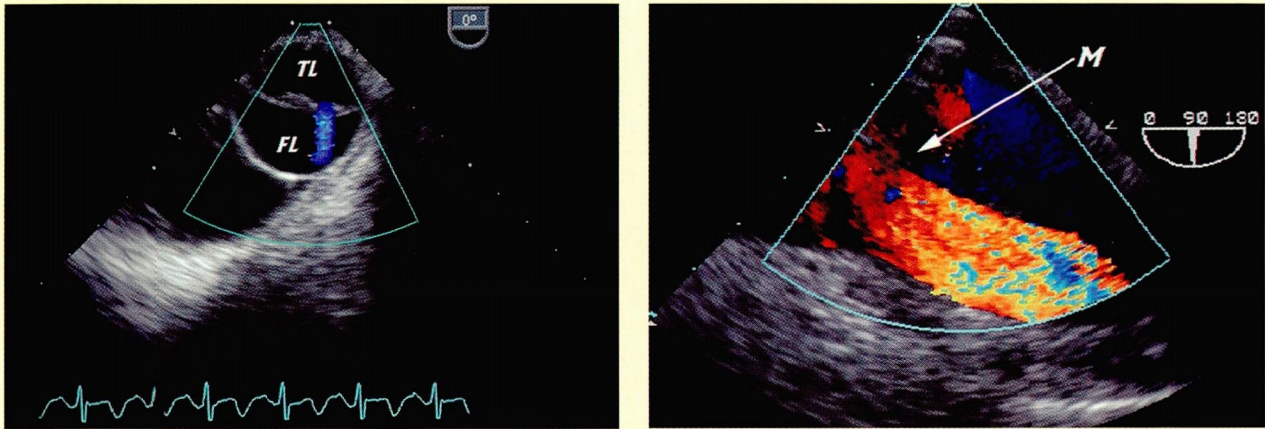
Dissection of the descending aorta. Left, short-axis view. The dissection membrane is seen, separating the true lumen (TL) on top from the false lumen (FL) at the bottom. Flow across an entry site (in blue, indicating flow from top to bottom) is seen on color Doppler flow mapping. Right, long-axis view in a different patient. The true lumen is at the bottom and the false lumen is on top, separated by the dissection membrane (M). On color Doppler, higher flow velocities are seen in the true lumen than in the false lumen, which shows almost stagnant blood.
